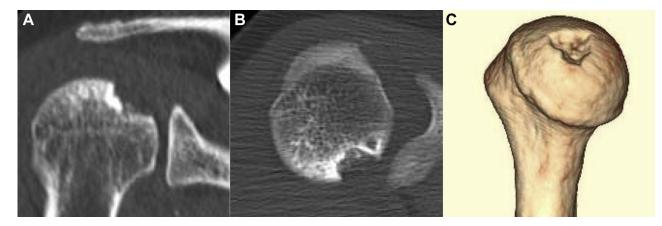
Preoperative computed tomography (CT) images of the right shoulder. A collapsed lesion was noted in the humeral head. (A) Oblique coronal image of the right shoulder. (B) Axial image of the right shoulder. (C) Reconstructed 3-dimensional CT of the right humerus.
